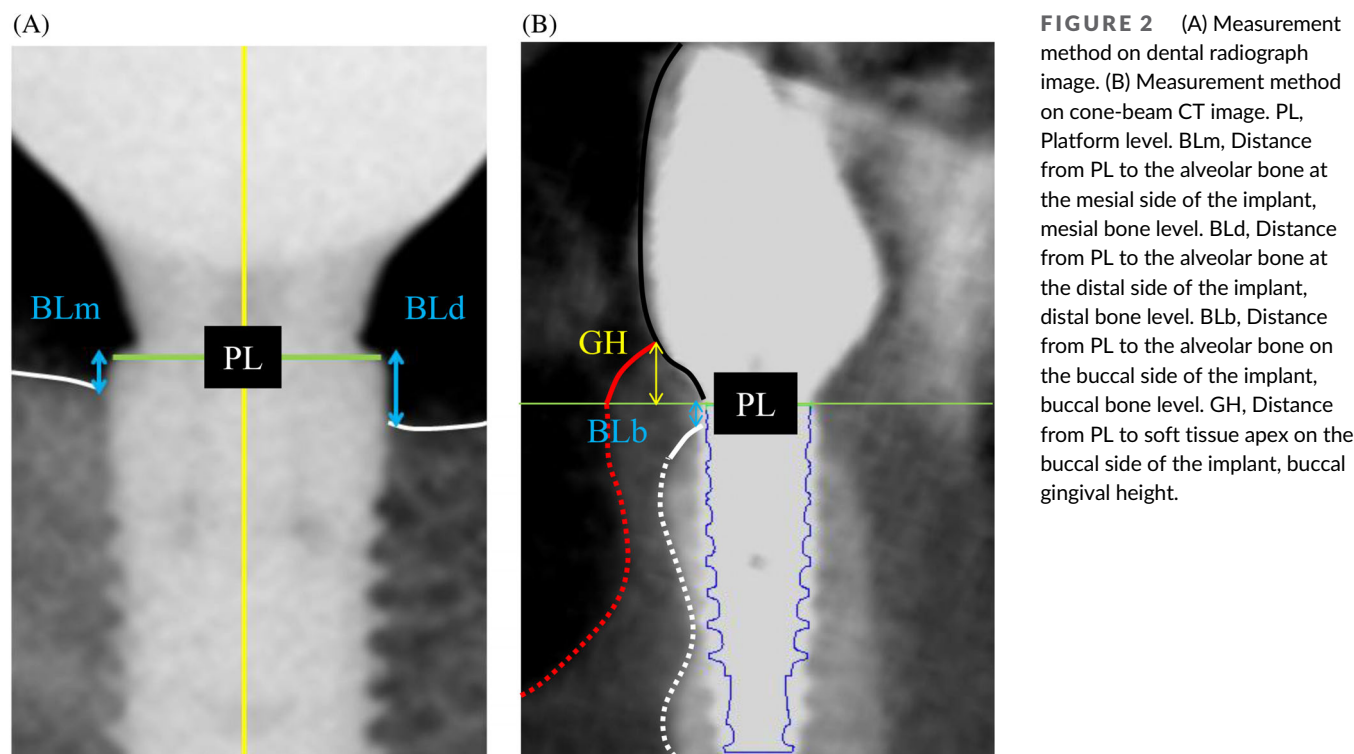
(A) Measurement method on dental radiograph image. (B) Measurement method on cone-beam CT image. PL, Platform level. BLm, Distance from PL to the alveolar bone at the mesial side of the implant, mesial bone level. BLd, Distance from PL to the alveolar bone at the distal side of the implant, distal bone level. BLb, Distance from PL to the alveolar bone on the buccal side of the implant, buccal bone level. GH, Distance from PL to soft tissue apex on the buccal side of the implant, buccal gingival height.
